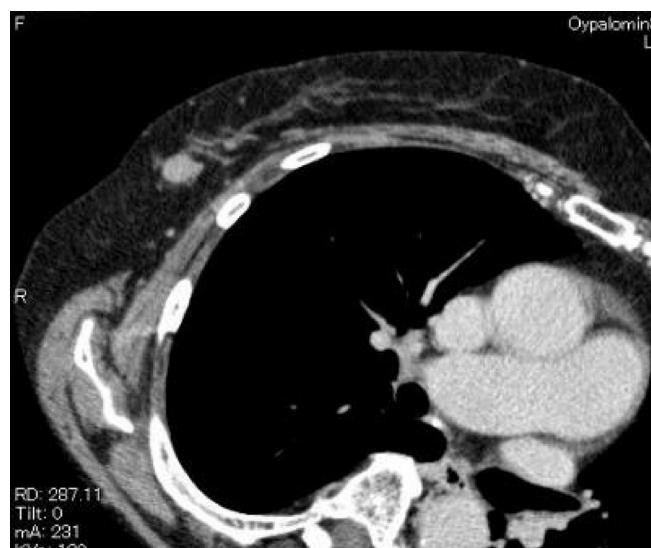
Contrast-enhanced axial CT of the chest shows a corresponding enhanced homogeneous breast mass.
